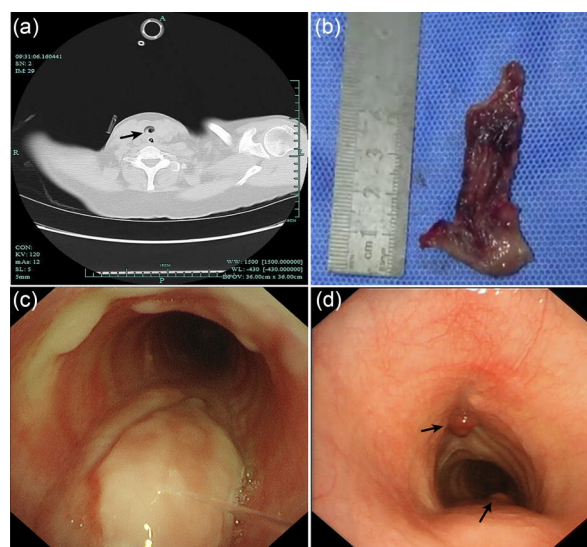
Imaging, gross morphology, and bronchoscopic data of the patient's mass. (a) The computed tomography (CT) scan image used to reconstruct the airway. Small circular patches of high density were seen in the tracheal lumen (arrow). (b) A 5-cm intratracheal strip mass was removed by intratracheal mass resection. (c) The results of bronchoscopy on postoperative Day 25 (3× magnification). The mucosa of the upper trachea was mildly swollen. (d) The results of follow-up bronchoscopy one month later (3× magnification). Nodular mucosal ridges in the tracheal wall were below the glottis (arrows).
